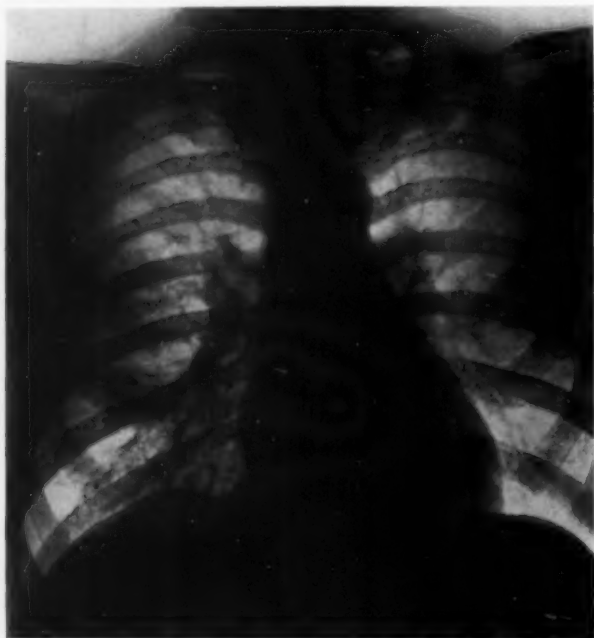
Cure by perforation of the abscess into a large bronchus. X-ray taken eight months later, complete disappearance of shadow.
